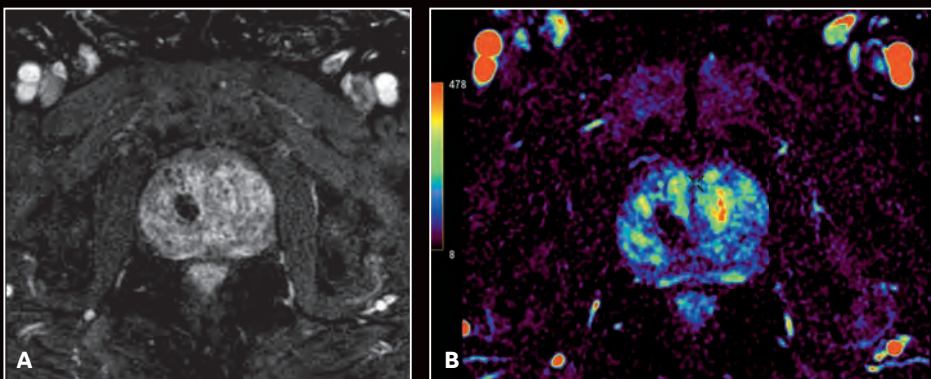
There is no enhancement in the dynamic sequence and restricted diffusion is consistent with a prostate abscess. (A) Axial DISCO LAVA; (B) enhancement integral map; (C) Axial DWI FOCUS b800; (D) ADC map; and (E) MAGiC DWI b1500.
